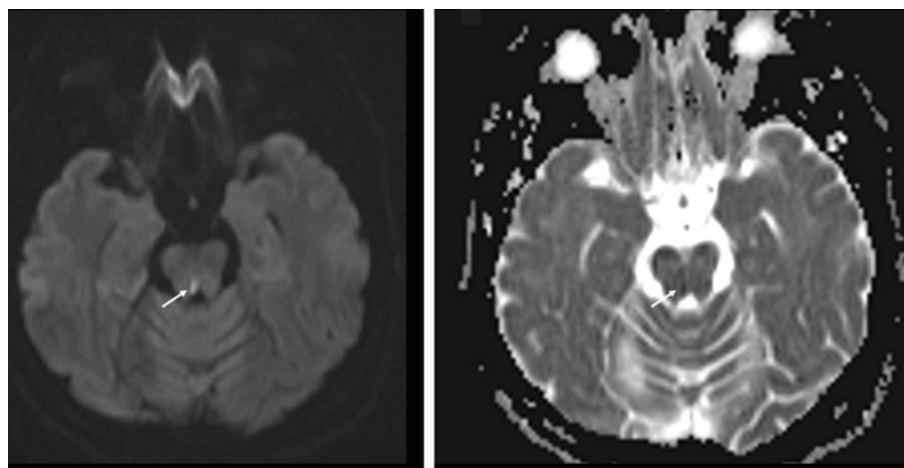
The second DWI, performed two days after the onset of symptoms, showing restricted diffusion in the right, inferior midbrain, just anterior to the cerebral aqueduct (arrows).
